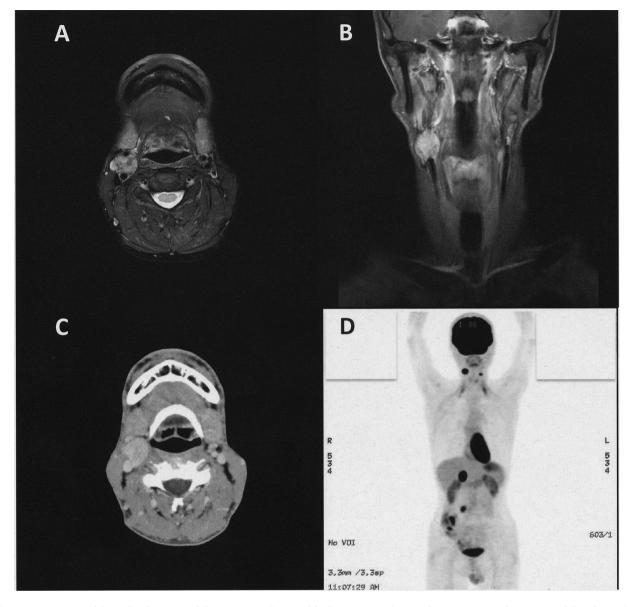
Imaging modalities for diagnosis of the patients with carotid body tumor. Axial (A) and anterior coronal (B) views of the T2-weighted magnetic resonance images of a carotid body tumor (CBT) of a 47-year-old male with succinate dehydrogenase SDHD variant. The tumor is located at the right carotid bifurcation, with an estimated size of  $26 \times 22 \times 21$  mm on the image. The tumor is located at the right carotid bifurcation and within the external and internal carotid arteries, suggesting a categorization as Shamblin type II. A small CBT was also observed at the left carotid bifurcation. Axial view (C) of the contrast-enhanced computed tomographic image of the same patient. A mixed pattern of enhancement was observed in the right CBT. The coronal image (D) in 18F-fluorodeoxyglucose positron-emission tomography of the same patient. Bilateral CBTs and a pheochromocytoma in his right adrenal gland were detected.
